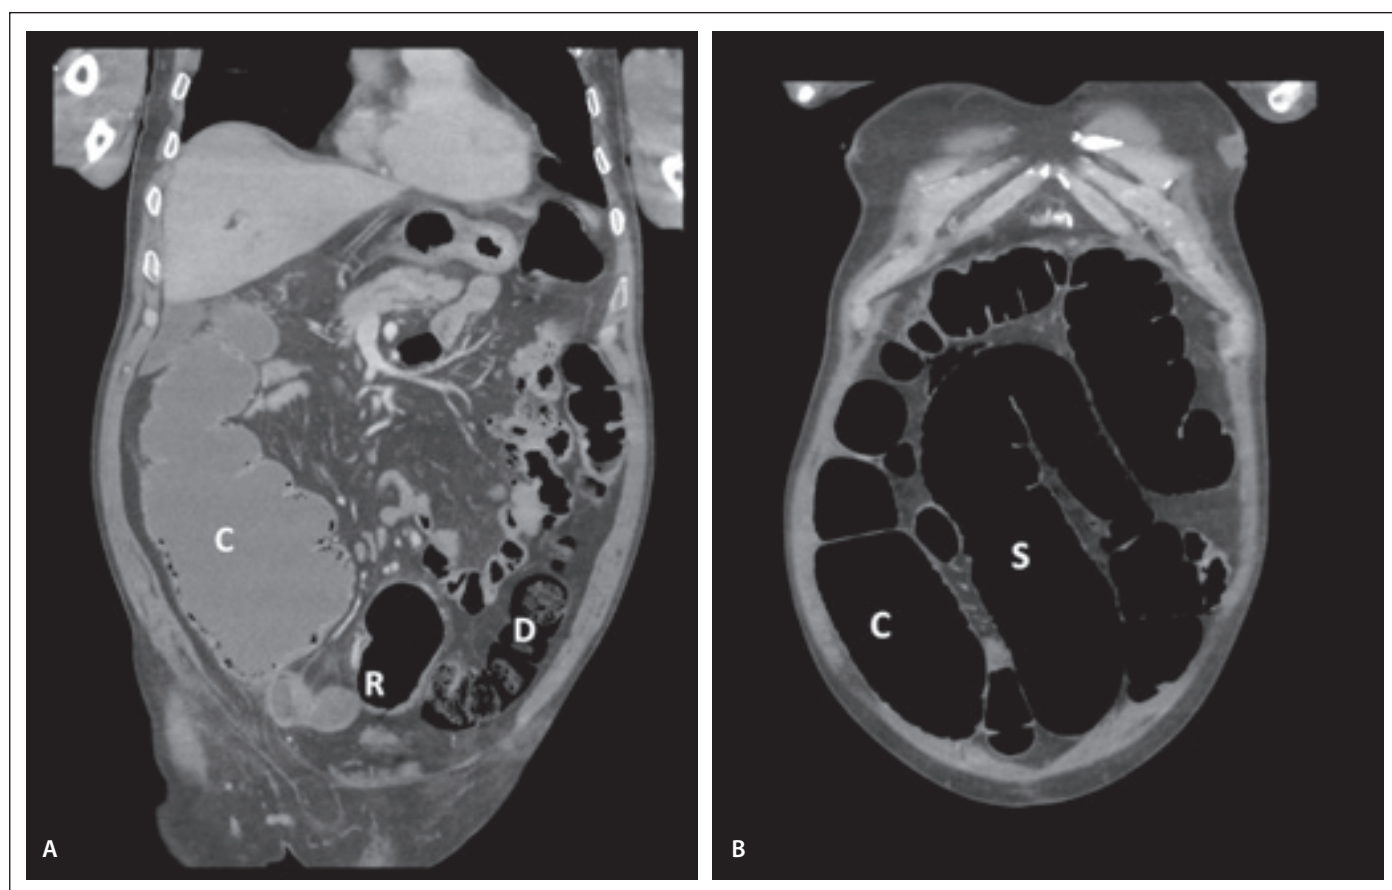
Postcontrast CT scan with a reconstruction of 3mm layers in the coronal plane. (A) Significant dilatation of the caecum with a fluid content. (B) Dilatation of the caecum and colon sigmoideum.
